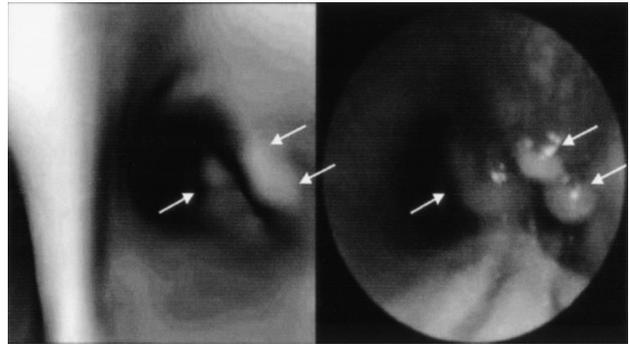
Virtual bronchoscopy. On the left is a 3-dimensional image of the airway lumen, constructed from computed tomography images. On the right is an actual bronchoscopy image of the same location. The arrows point to airway lesions. (From Reference 28, with permission.)
